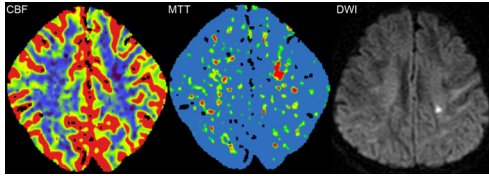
Whole-brain CT perfusion, now clinically available due to technologic innovations, improves diagnostic utility and makes possible the detection of small acute brain infarcts. The CT scans in this patient, specifically the cerebral blood flow and mean transit time images, were acquired 1.5 hours after symptom onset and reveal a small ischemic lesion in the left central semiovale. The lesion was confirmed by MRI (DWI), which was performed 2 days later. Reprinted with permission from Thierfelder et al.¹³ Figure 1 can be viewed online in color at www.investigativeradiology.com.
